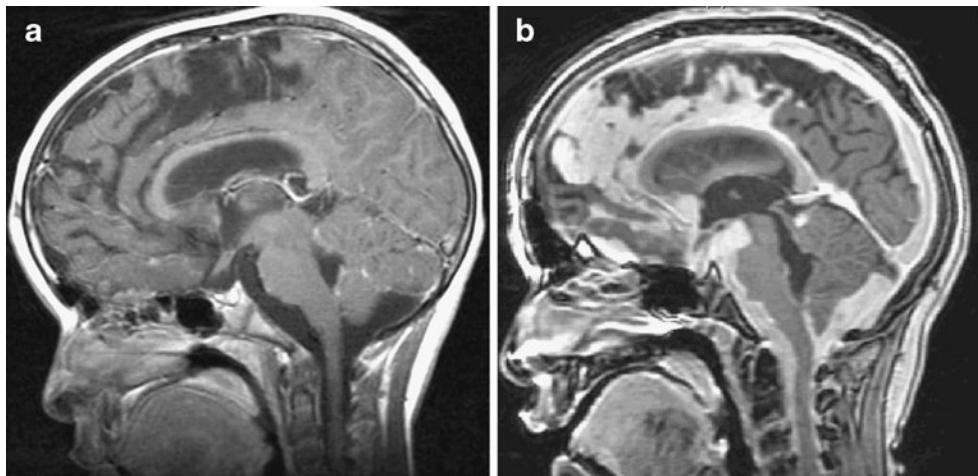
a T1-weighted sagittal MRI of the brain with contrast 4 years prior to admission, at the time of presentation with suspected sterile meningitis. b T1 sagittal MRI scan of the brain with contrast revealing
